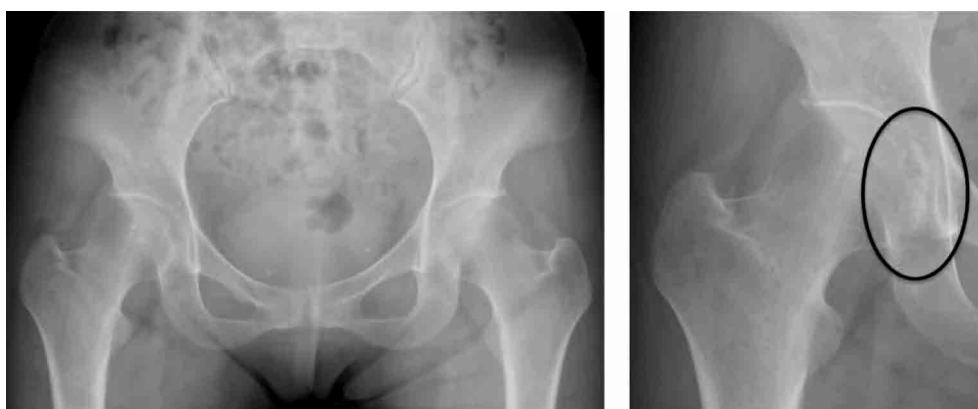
Plain anteroposterior radiographs reveal a radiopaque lesion in right hip joint space after careful searching.
